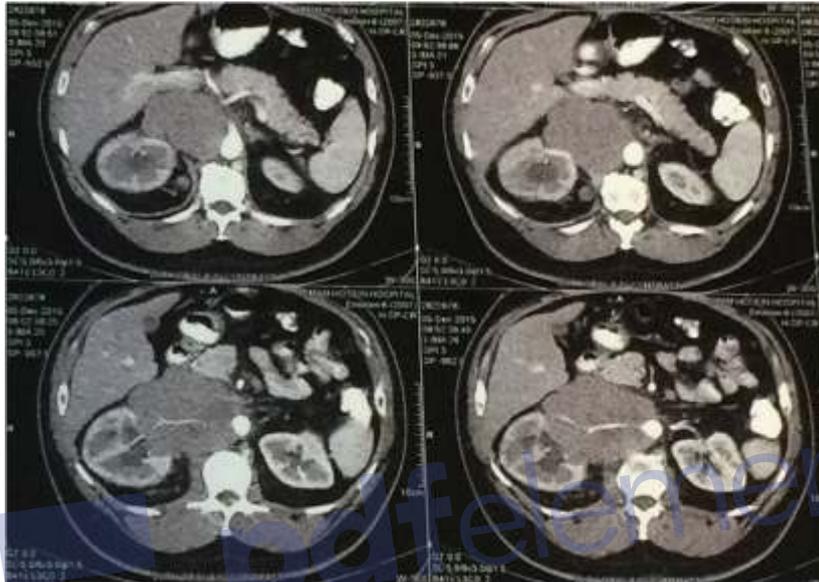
CT scan images before chemotherapy show thrombosis inside the IVC, below the mass and perinephric lymph node
